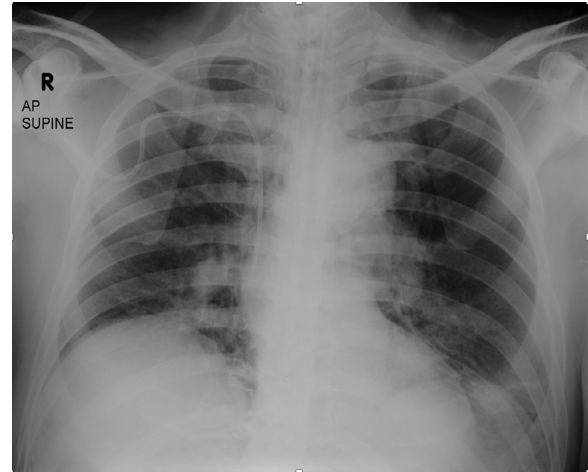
Chest X-Ray AP view on day 1 admission showing opacities at the right and left lower lobe region (blue arrow) of the lungs consistent with bilateral Pneumonia (color version of figure is available online.)
